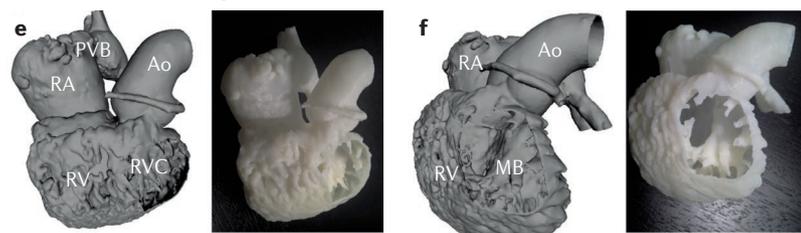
3D printing applications for patients with congenital heart disease. a,b | Physical model application in an ostium secundum atrial septal defect. After the implantation of a 17 mm AMPLATZER Septal Occluder (St. Jude Medical, USA), a CT-derived 3D-printed model showed that the occluder adequately filled the atrial septal defect without interfering with the venous inlets, and was perfectly aligned with the interatrial septum (panel a). The left-sided counteroccluder contacted, but did not indent, the aortic wall or the left atrium (LA) roof (panel b). c,d | Flexible 3D-printed models of hearts from infants with double outlet right ventricle (RV) that enable straightforward appreciation of the anatomical relationships (panel c), as well as for hands-on training of the surgical repair of the condition, including suturing of the ventricular septal defect (VSD) patch (panel d). e,f | 3D models of a patient after Mustard procedure. A 3D virtual model (left) and corresponding printed model (right) of the pulmonary venous baffle (PVB) to the systemic RV in a patient aged 36 years with dextrotransposition of the great arteries (d-TGA) after Mustard procedure in heart failure. The model is viewed from the anterior aspect (panel e) and the leftward aspect (panel f). The anatomical landmarks of interest — the prominent trabeculations of the systemic RV and the moderator band (MB) — were well reproduced. This procedure enables presurgical planning of cannula placement to avoid possible inflow obstruction as a result of these trabeculations. Ao, aorta; IVC, inferior vena cava; LV, left ventricle; PA, pulmonary artery; RA, right atrium; RVC, right ventricular cavity; RVOT, right ventricular outflow tract. Panels a and b are reprinted from Bartel, T. et al. Three-dimensional printing for quality management in device closure of interatrial communications. *Eur. Heart J. Cardiovasc. Imaging* 17, 1069–1069 (2016) with permission from Oxford University Press and the ESC. Panels e and f are reprinted from Farooqi, K. M. et al. 3D printing to guide ventricular assist device placement in adults with congenital heart disease and heart failure. *JACC Heart Fail.* 4, 301–311 (2016) with permission from Elsevier.
